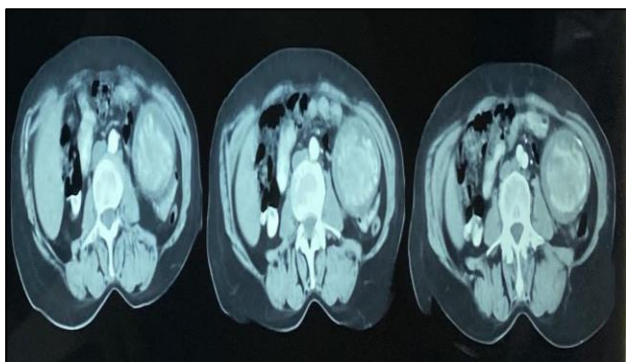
CT scan demonstrating a hyperdense oval image.
